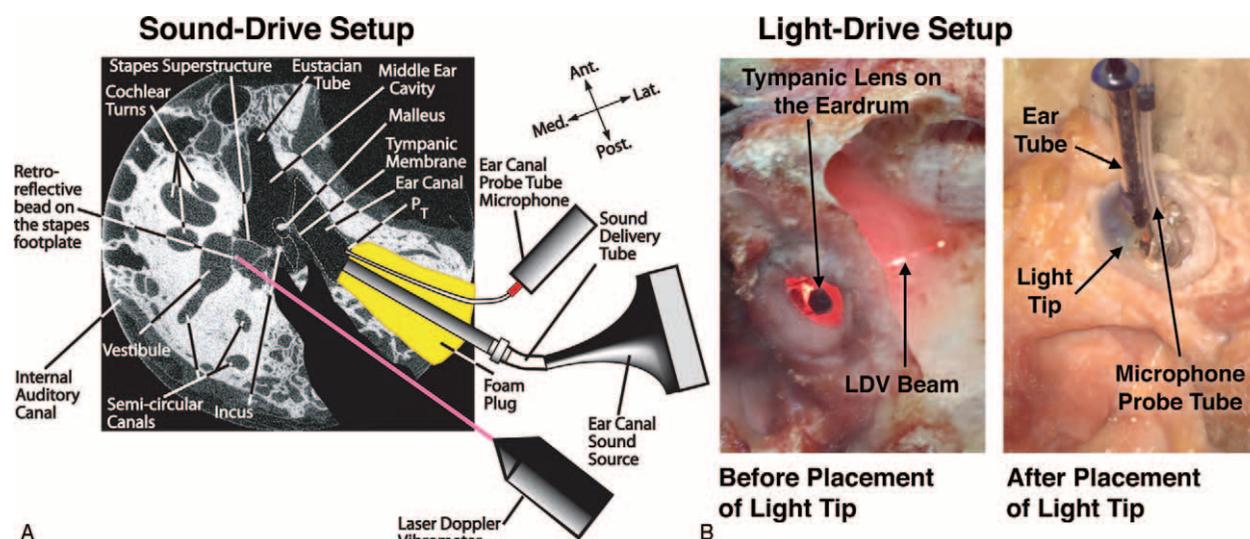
Sound-driven (A) and light-driven (B) setups used for the temporal-bone experiments. A probe-tube microphone was used to measure ear-canal pressure (P_T) within 2 to 3 mm of the tympanic membrane (TM) or Lens, and a Polytec HLV-1000 laser Doppler vibrometer (LDV) was used to measure stapes velocity (V_S). (A) Setup for the baseline case of sound-driven stimulation (unaided), both without the Lens in place and with the Lens in situ on the TM (not shown). (B) Setup for light-driven cases using a custom-shaped Lens and Light Tip with the laser light source of the Light Tip within 3 mm of the Lens' photodiode.
